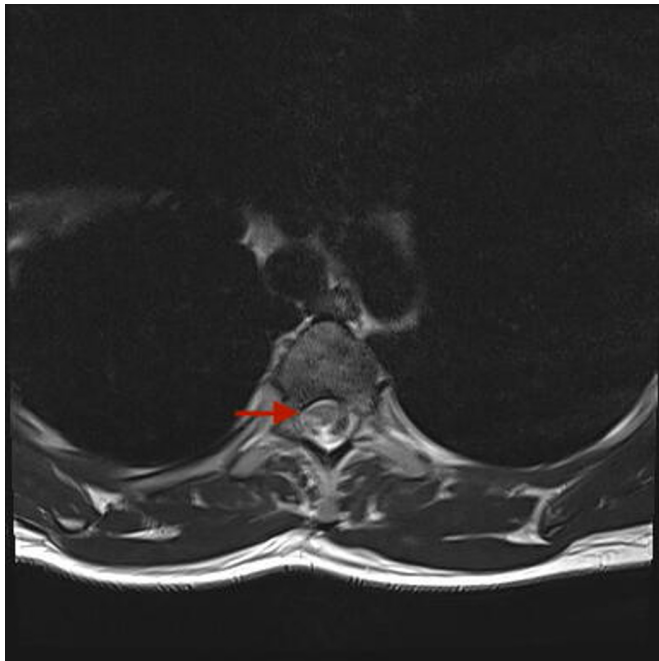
Axial image of gadolinium-enhanced MRI done on admission showing T2-weighted image hyperintensity lesions at the thoracic level involving the central and peripheral region of the spinal cord.
